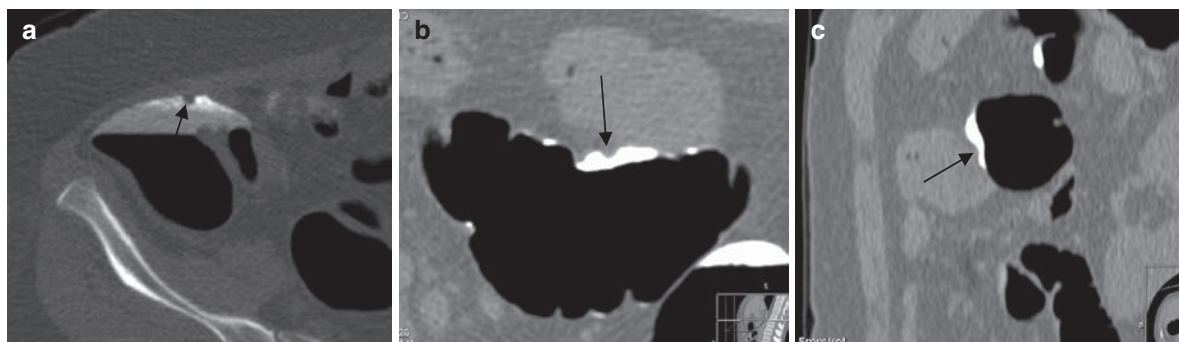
Submerged sessile polyps in two patients, both seen as a negative filling defect in the midst of tagged fluid (arrows). (a) A submerged polyp in the cecum on prone axial CT colonography image corresponding to a tubular
